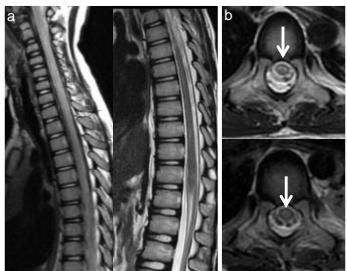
Radiologic MRI Studies in Transverse Myelitis
